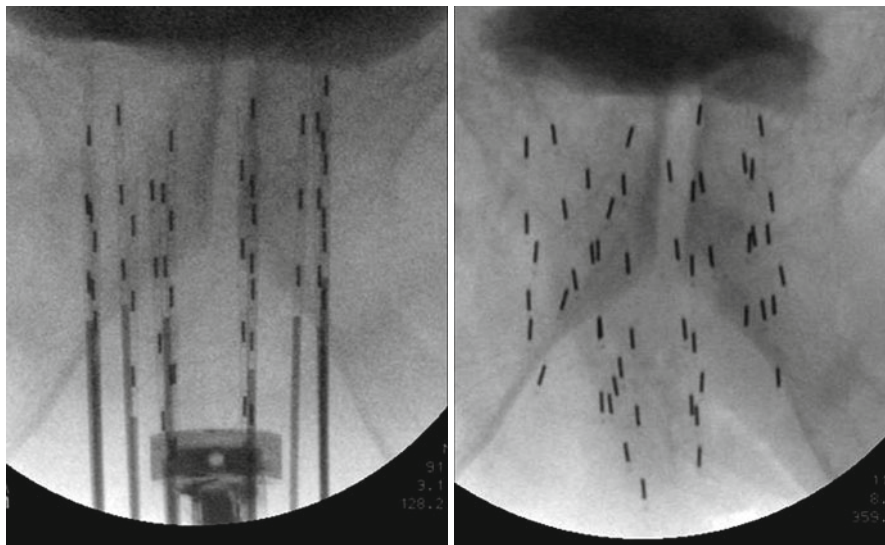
Radiographs before and immediately after source insertion
